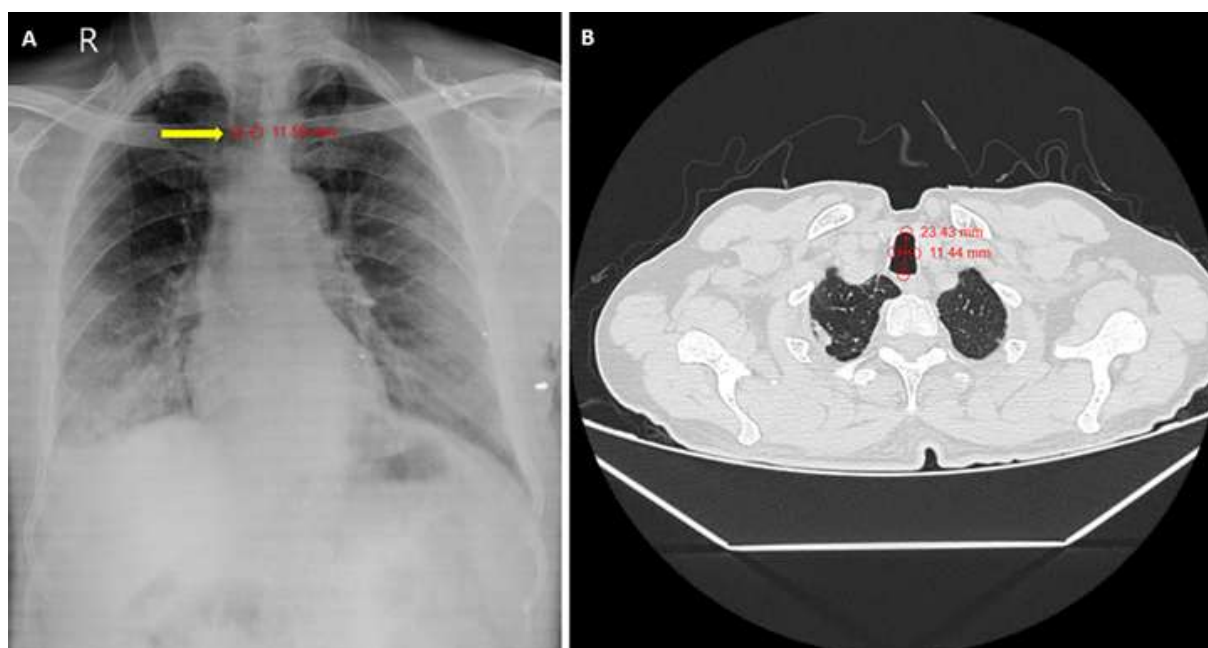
A) chest radiograph showing narrowing of the intrathoracic tracheal column; B) axial high-resolution computed tomography demonstrating coronal narrowing with sagittal widening consistent with saber-sheath trachea
